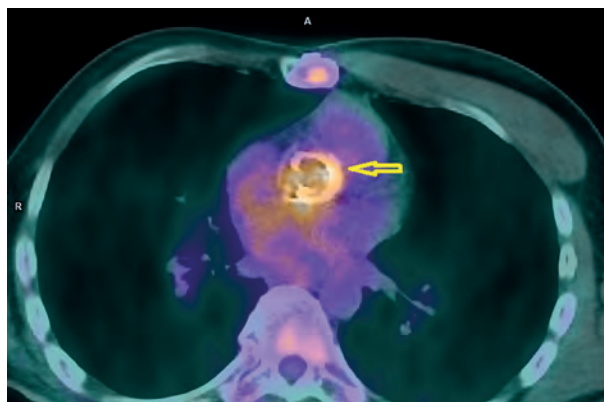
Fusion images of PET/CT performed to diagnose infective endocarditis. Images were acquired with a Biograph 64 PET/CT scanner (Siemens Medical Solutions, Inc.) 60 minutes after injection of 330 mBq [^{18}F]FDG. Presented image shows a transversal, fused PET/CT image, corrected for attenuation. Yellow arrow shows increased radiotracer uptake in the aortic annulus consistent with infection. The semiquantitative PET/CT analysis was performed using the SYNGOVIA application. Standardized uptake value (SUV_{max}) for valve area was 3.4; reference (myocardial blood pool [MBP] was 2.1, liver SUV_{max} 2.9)
